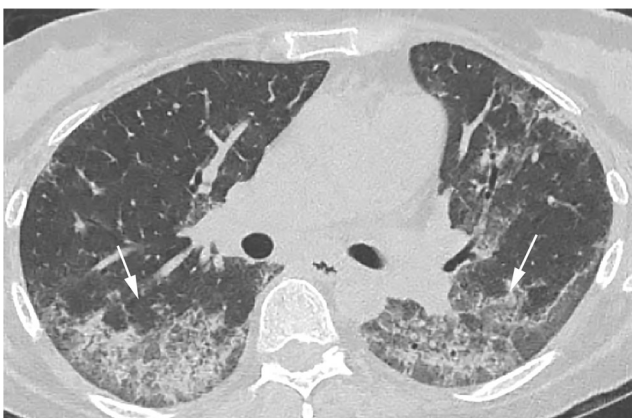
HRCT of an SLE patient with acute pneumonitis shows bilateral, patchy areas of ground-glass opacity mixed with reticular abnormality (*arrows*). HRCT high-resolution computed tomography, SLE systemic lupus erythematosus
